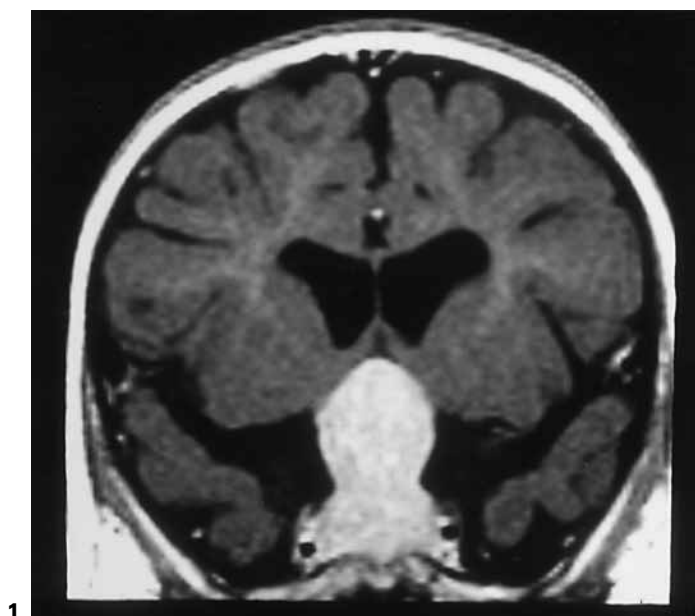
Magnetic resonance imaging of the pituitary adenoma. T₁-weighted coronal (1) and sagittal (2) showing a 2 × 2 × 3 cm measuring, contrast enhancing lesion with intra- and suprasellar extension.
